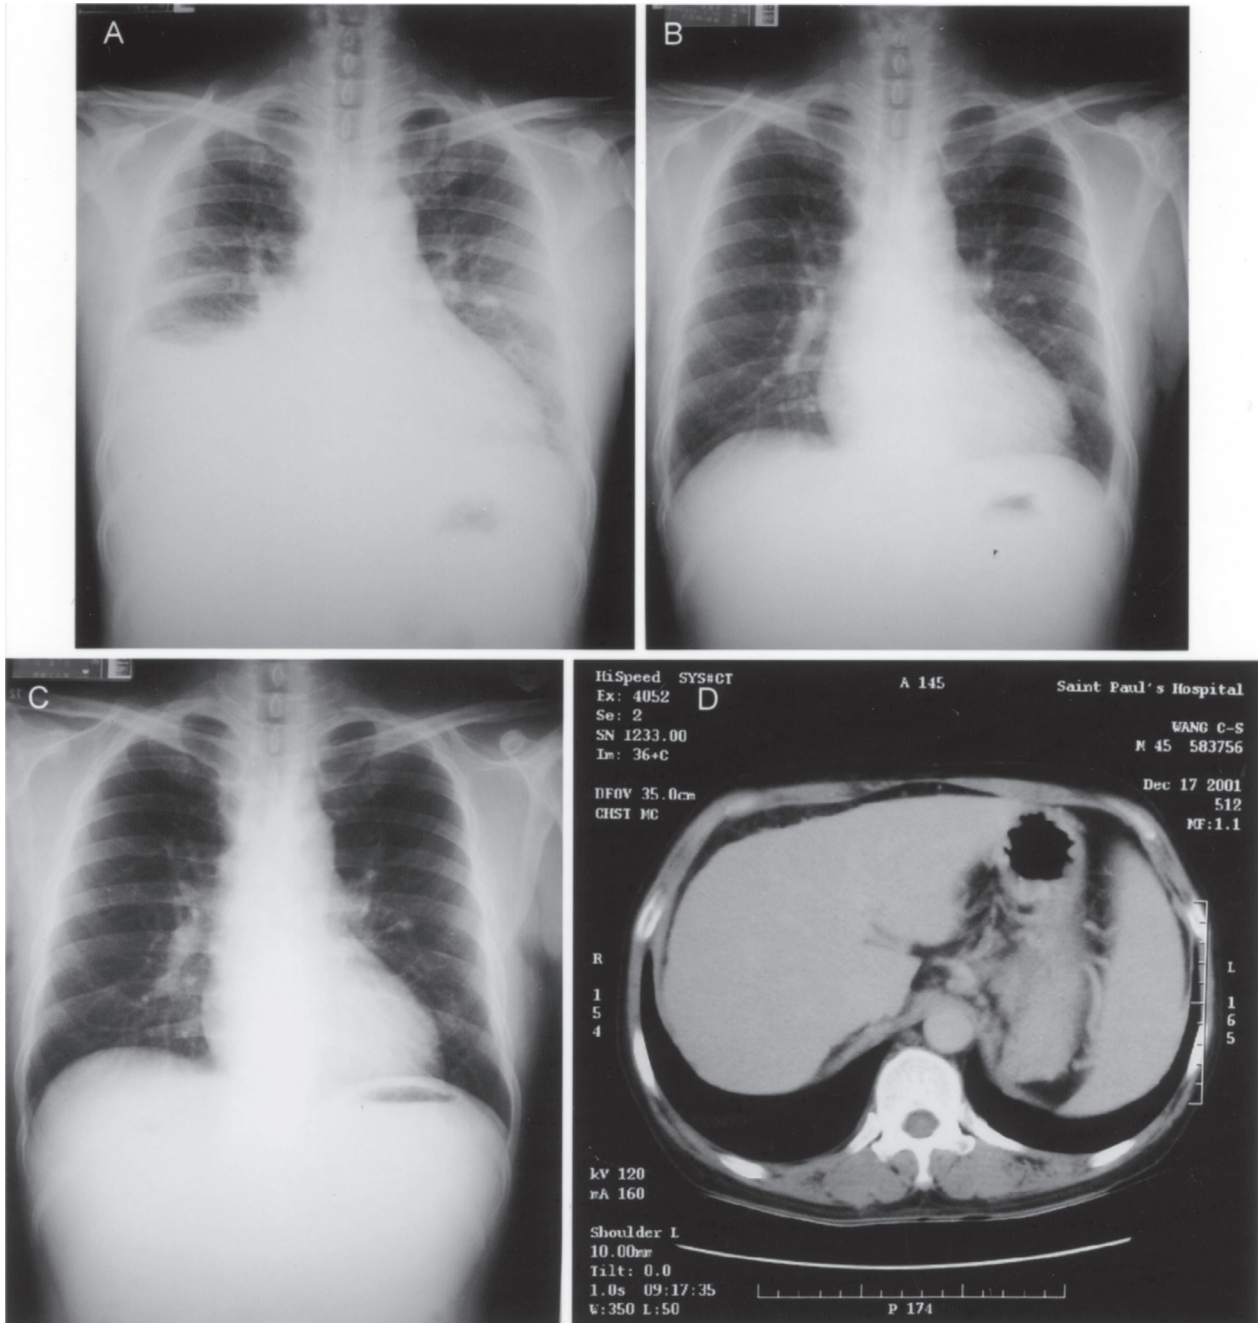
Chest radiography (A) pulmonary congestion with a moderate amount of right side pleural effusion (B) clear lung fields with only minimal pleural effusions in the bilateral costophrenic angles and a normal cardiothoracic ratio after 2 weeks' diuretic treatment (C) clear lung fields with sharp bilateral costophrenic angles and a normal cardiothoracic ratio 1 week after discharge (D) computed tomography showed no lymphadenopathy or solid tumor.
